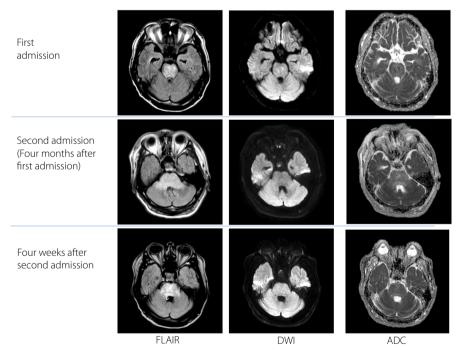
Magnetic resonance imaging of the brain. Upper row, the first admission. Fluid-attenuated inversion recovery imaging showed swelling of the pons with hyperintense signals sparing the marginal area. Diffusion-weighed imaging showed a small, restricted diffusion area in the pons with a reduced apparent diffusion coefficient, indicating cytotoxic edema. Middle row, the second admission (4 months after the first admission). Hyperintense signal in swollen pons was observed on fluid-attenuated inversion recovery image, with slightly increased apparent diffusion coefficient, indicating vasogenic edema. Lower row, 4 weeks after the second admission. Left column, fluid-attenuated inversion recovery image (FLAIR); middle column, diffusion-weighed imaging (DWI); right column, apparent diffusion coefficient image (ADC).
